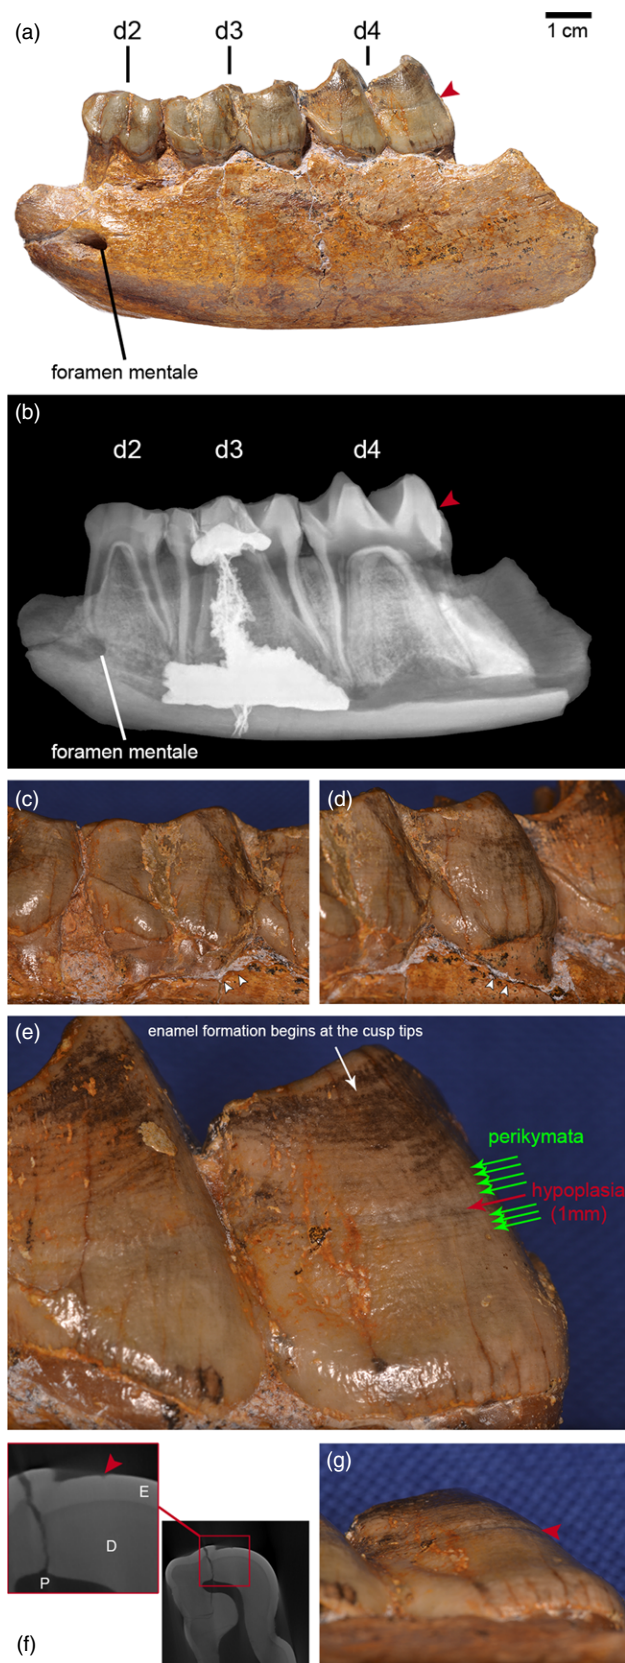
SNSB-BSPG 1959 II 2261 of *Prosantorhinus germanicus*. (a) In lateral view: the left mandible contains three completely erupted deciduous cheek teeth *in situ* (d2, d3, d4). (b) The latero-lateral X-ray proved absence of premolar germs. (c and d) The detailed view of the mandible shows that the roots of the deciduous cheek teeth are partially exposed because the mandibular bone is damaged (supposedly by post-mortem destructive factors, such as erosion). (e) The striae of Retzius (or incremental lines) end at the surface of dental enamel and appear as shallow furrows, the perikymata, in d4. A clearly visible, deep trench in the dental enamel encompasses the entire d4. (f and g) The detailed view of the tooth and the μ CT images reveal that this trench is confined to the enamel and does not affect the underlying dentin. Based on this, a linear enamel hypoplasia, a quantitative enamel deficiency, is assumed.
